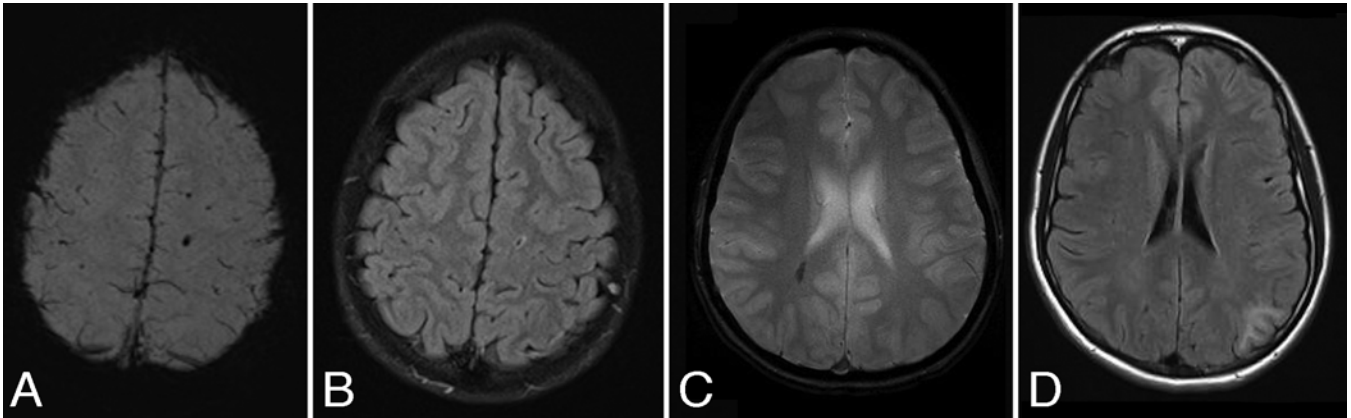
Traumatic structural brain abnormalities identified on neuroimaging in patients with SRC. Axial susceptibility-weighted (A) and FLAIR (B) MR images obtained in a 13-year-old boy presenting with posttraumatic seizure and right-sided Todd's paralysis after he sustained a concussion playing dodgeball, demonstrating focal left frontal intraparenchymal hemorrhage. Axial gradient recalled echo MR image (C) acquired in an 11-year-old boy presenting with persistent headaches following hockey-related concussion, demonstrating intraparenchymal hemorrhage within the occipital white matter. Axial FLAIR MR image (D) obtained in a 14-year-old girl presenting with formal neuropsychological deficits following Ringette-related concussion. Features are consistent with nonhemorrhagic intraparenchymal contusion. All patients were advised to retire from contact and collision sports based on imaging findings. Panels C and D are reproduced from Ellis et al.: *J Neurosurg Pediatr* 16:241–247, 2015. Published with permission.
